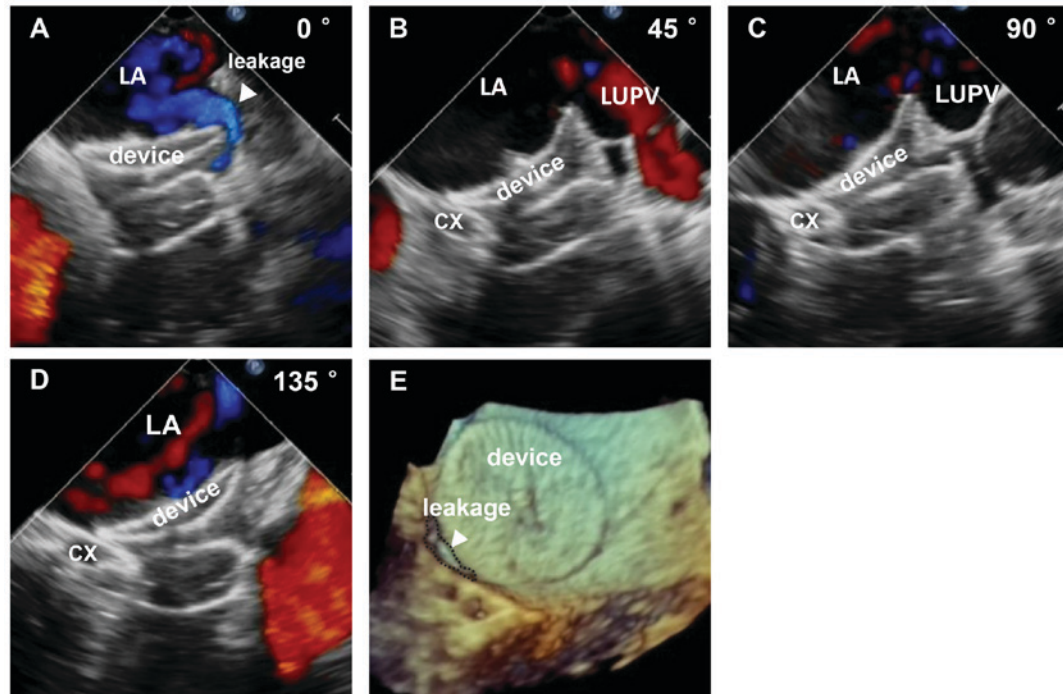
Images of peri-device leakage detected by (A-D) two dimensional TEE and (E) real time-three dimensional TEE. TEE, transesophageal echocardiography; LA, left atrium; CX, circumflex artery; LUPV, left upper pulmonary vein.
